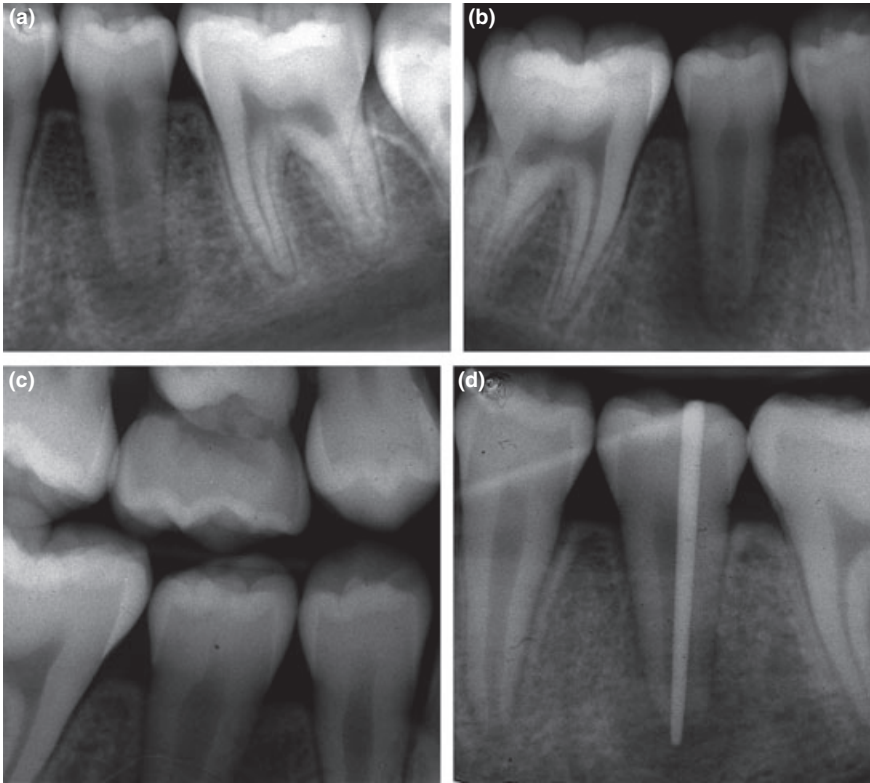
(a,b) Radiographic examination demonstrated incomplete root formation and diffuse periapical radiolucencies of 6 × 6 mm in size in both mandibular second premolars. (c) No carious lesion was diagnosed. (d) A gutta-percha point was used to trace the sinus tract and a periapical radiograph was taken, demonstrating the association between the drainage and the periradicular radiolucency.
